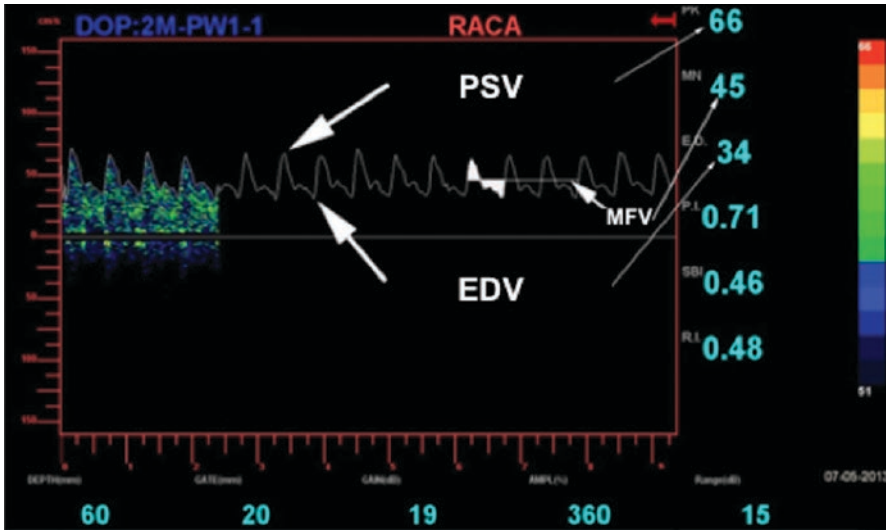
On the left you can see a Doppler spectrum velocities (sonogram) in the first four cycles. In the following cycles the spectrum has been erased and only the envelope wave is seen. The arrows show the point where the PSV, the EDV and the MFV. You can also see the graphical calculation of the average velocity which in this case coincides with the value calculated by the equipment since the envelope wave correctly follows the maximum values of the Doppler spectrum. The average velocity calculated graphically is the one that marks a horizontal line that divides the envelope wave in two parts of similar area as seen in the figure
